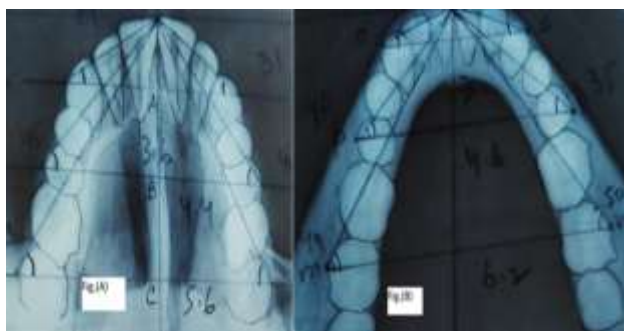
A,B: showing tracings of standard occlusal radiographs.
